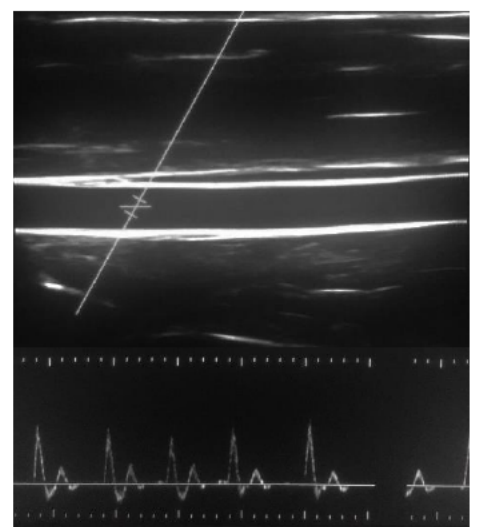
Example longitudinal image of the brachial artery, with clear arterial walls and strong pulsed wave Doppler signal.
